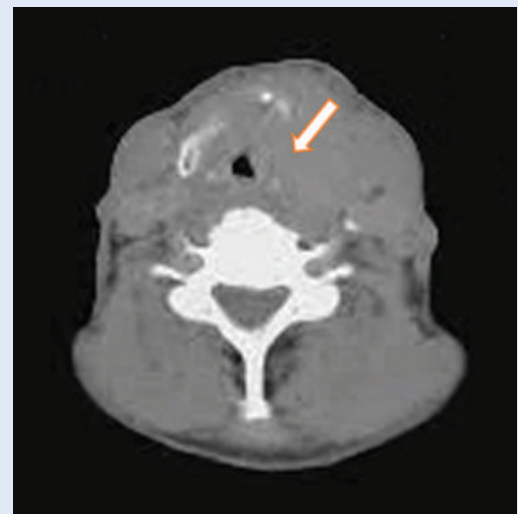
Axial section of positron emission tomography with native low dose computed tomography scan demonstrating tumor mass infiltrating the thyroid cartilage and the left vocal fold (arrow) – showing progression of the tumor mass from the supraglottic to the glottic area in comparison with figure 1.
